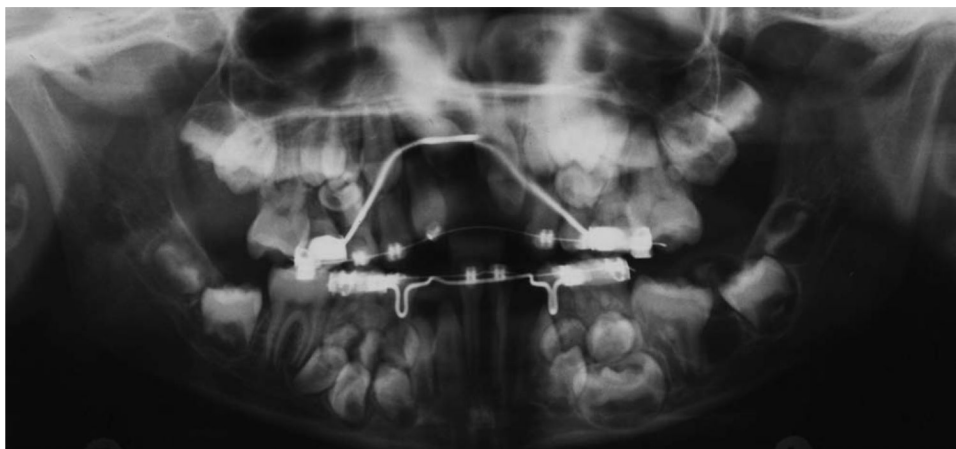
Panoramic radiograph showing multiple impacted supernumerary teeth in the nine-year-old male with cleidocranial dysplasia. Orthodontic alignment is required to keep sufficient space in the dental arch for further treatment. (Courtesy of Bonnie L. Padwa, DMD, MD, Children's Hospital Boston, Harvard Medical School).
